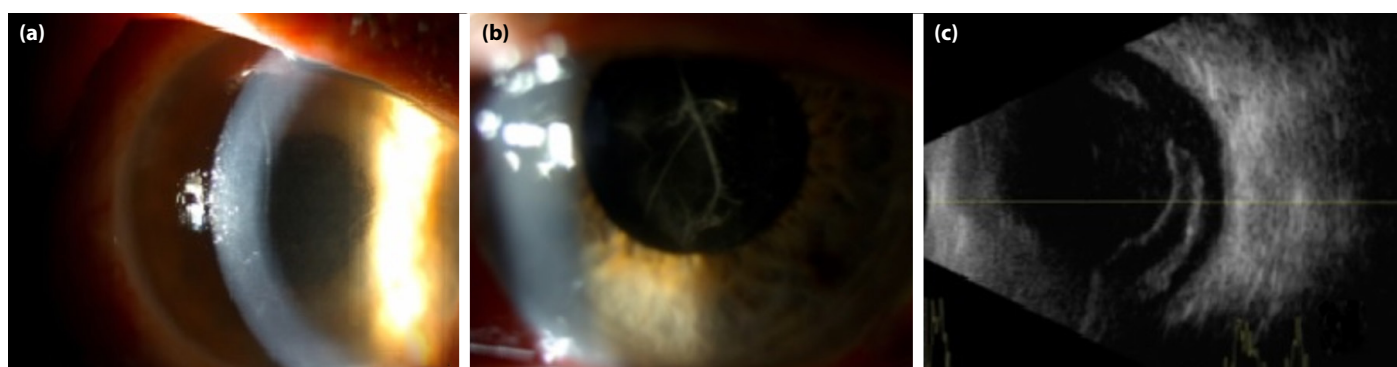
(a) Case 1 was admitted with corneal edema and Descemet's membrane folds; (b) +4 cellular reaction and fibrin formations in the anterior chamber; (c) condensed view in the vitreous on ocular ultrasound.
